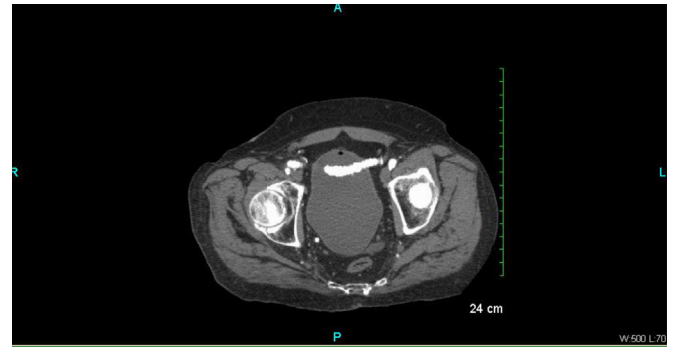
CT angiogram confirming the graft crossing through the bladder.
